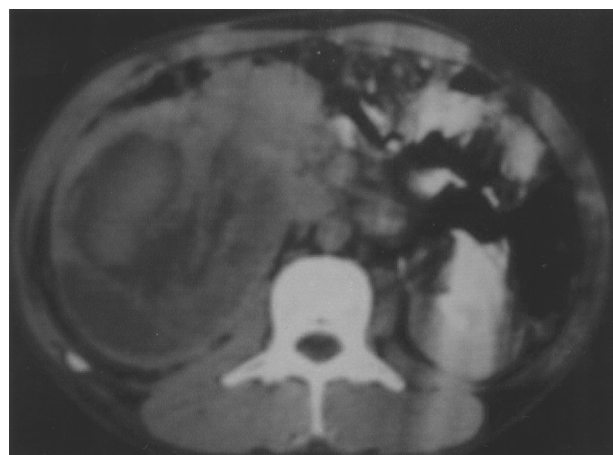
Abdominal computed tomography evidencing a voluminous tumoral mass in right kidney.
